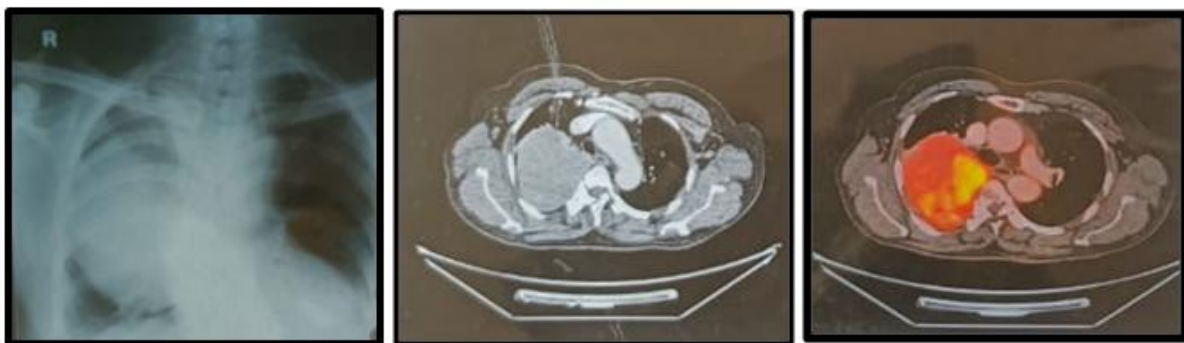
CHEST XRAY, CT THORAX, PET CT
